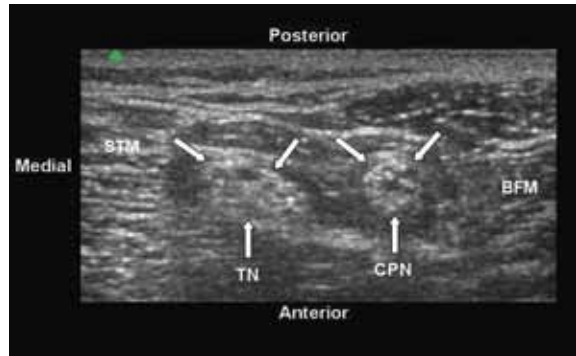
Ultrasound image of the common peroneal nerve and tibial nerve just distal to the division of the sciatic nerve, 5 cm proximal to the popliteal crease.
